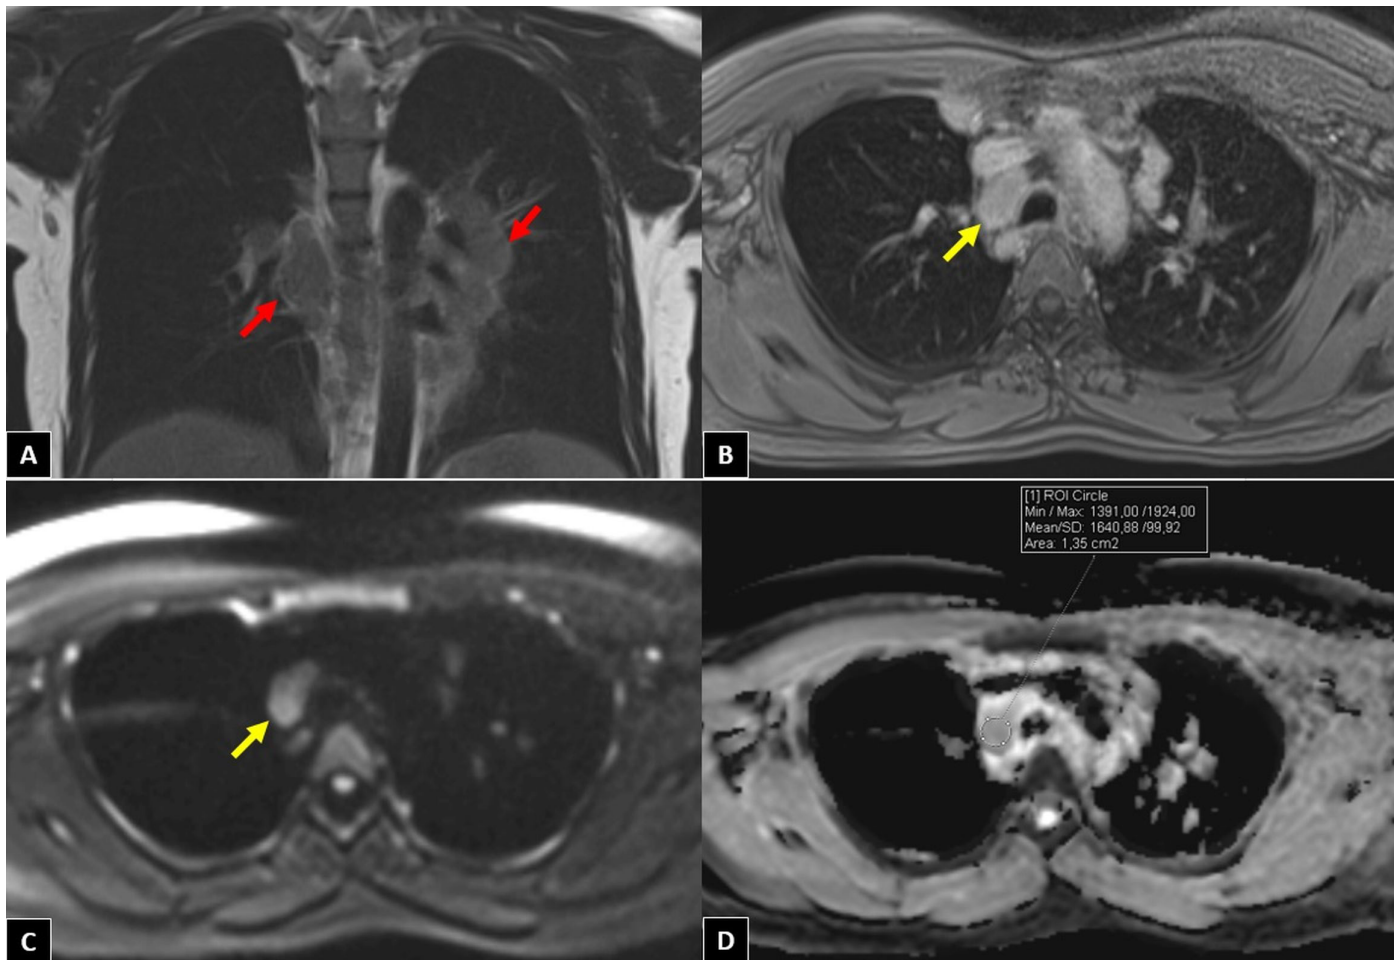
A 38-year-old patient with sarcoidosis. (A) Coronal T2W magnetic resonance (MR) image shows multiple bilateral hilar lymphadenopathy (red arrows); (B) axial post-contrast T1W MR image shows hyper-enhancing right upper paratracheal lymph node (yellow arrow); (C) $b=800$ s/mm² diffusion-weighted MR image shows hyperintense right upper paratracheal lymph node (yellow arrow); (D) in the ADC map image, the mean ADC value of this lymph node was measured as 1.64×10^{-3} mm²/s.
